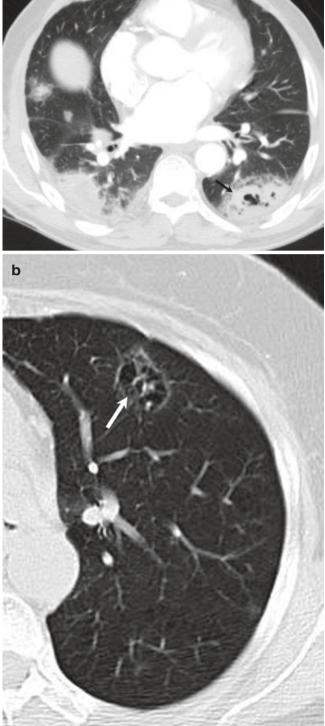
Pseudocavitation or bubbly lucencies in two patients. (a) Axial CT image in a patient with mucinous colonic cancer with multiple pulmonary metastases with one in left lower lobe showing pseudocavitation (arrow). (b, c) Axial CT images in a 35-year-old woman with a cystic mass due to pseudocavitation (arrow) that was proven to be an adenocarcinoma
